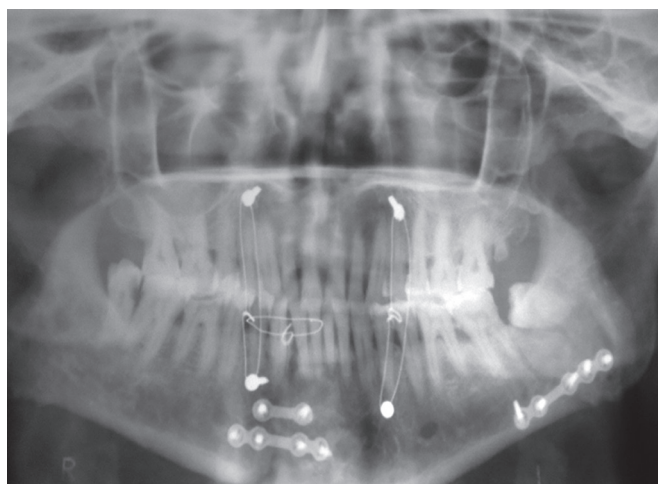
Postoperative orthopantomogram
